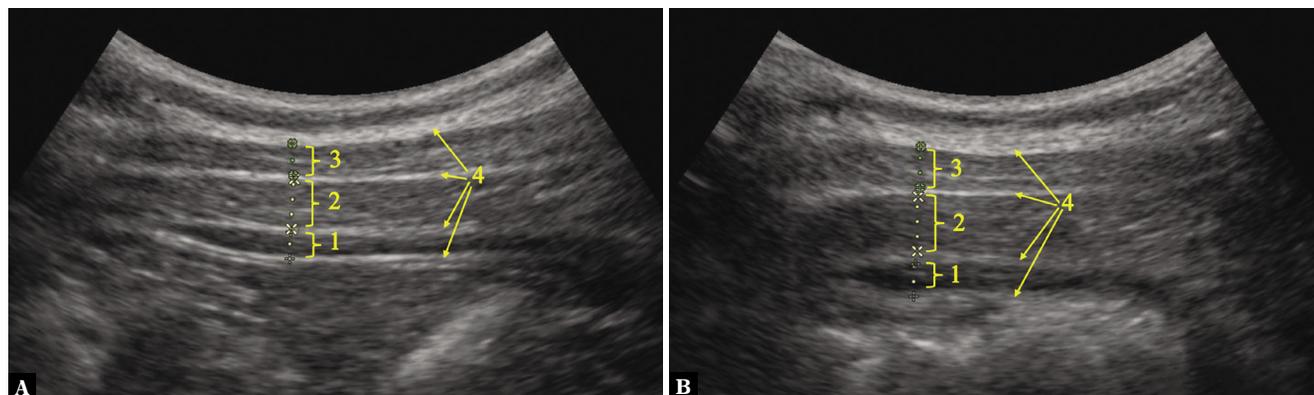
Sonography image of the transverse abdominis, and the internal oblique and external oblique muscles A. Rest condition. B. Abdominal draw in maneuver. 1 – transverse abdominis; 2 – internal oblique; 3 – external oblique; 4 – fascial layer
